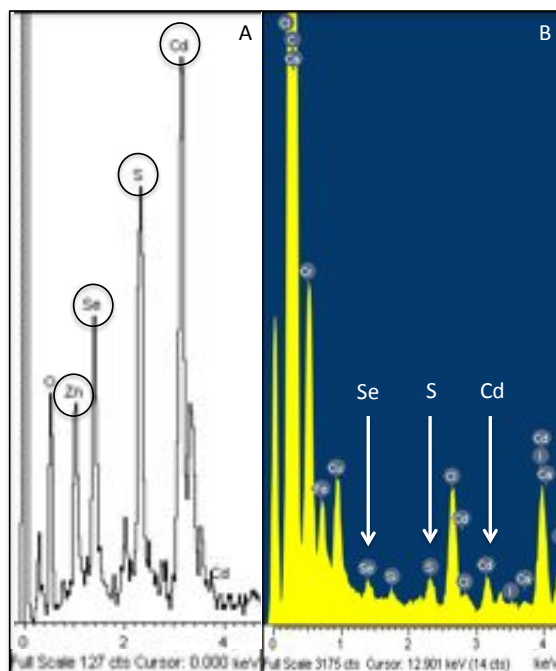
X-Ray microanalysis of the (A) Quantum Dots and the (B) QD-functionalized rCNTs.
